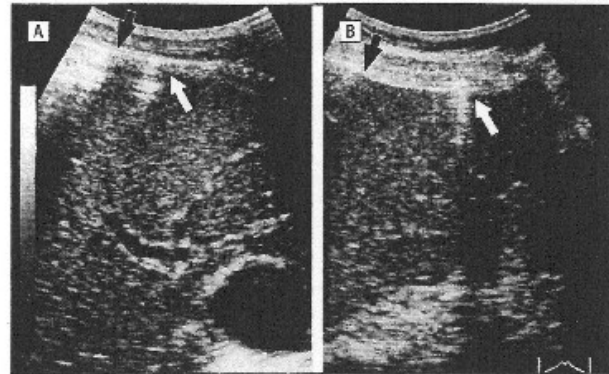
Ultrasonography findings showing subcutaneous emphysema (A) and intermuscular emphysema (B) mimicking intraperitoneal free air (IPFA) (white arrows in both A and B), which can be differentiated from IPFA by the origin of the shadow in the peritoneal wall or immovability in response to compression of the probe
